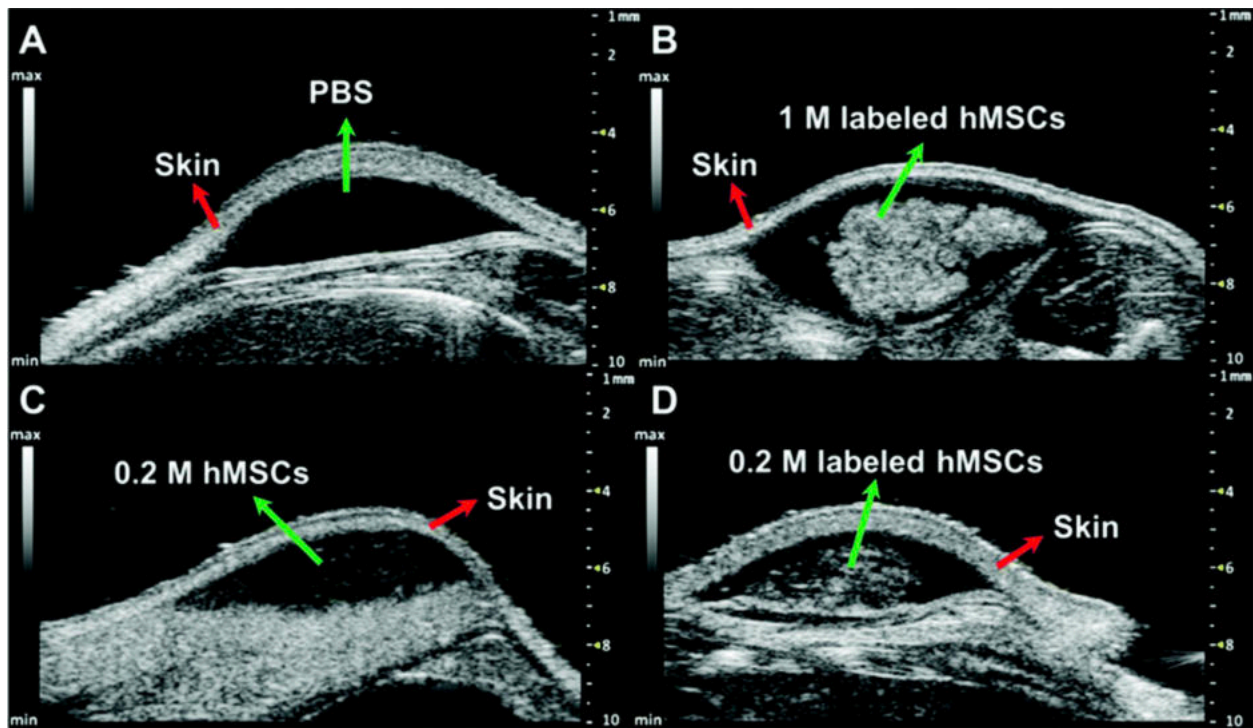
Ultrasound images and *in vivo* quantification of cells echogenicity. *In vivo* ultrasound images of (A) PBS, (B) 1 million ELS-labelled hMSCs, (C) 0.2 million unlabelled hMSCs, and (D) 0.2 million ELS-labelled hMSCs. Image copyright from Chen *et al.* [168].
